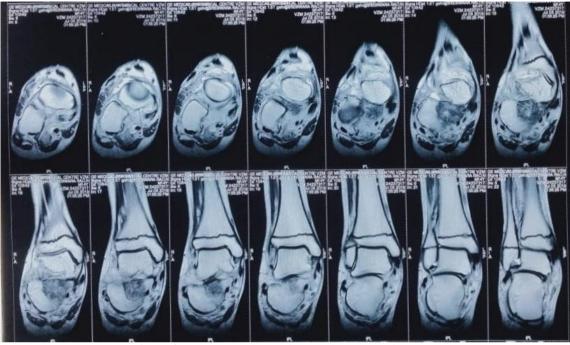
MRI coronal cuts showing lesion in calcaneum.
